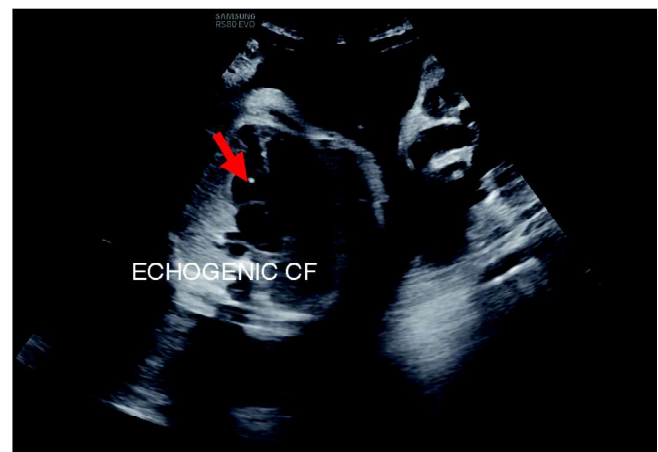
2D gray scale ultrasound images of fetal heart 4 chamber view showing echogenic intracardiac focus in left ventricle of fetus.
